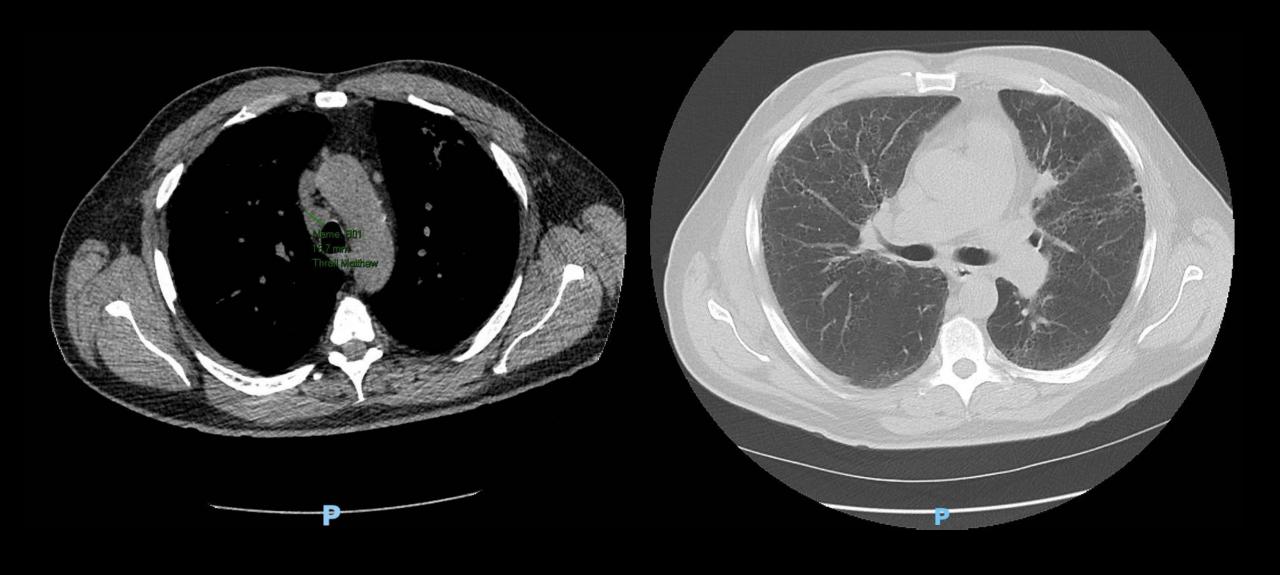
Low-dose CT scan (LDCT).
